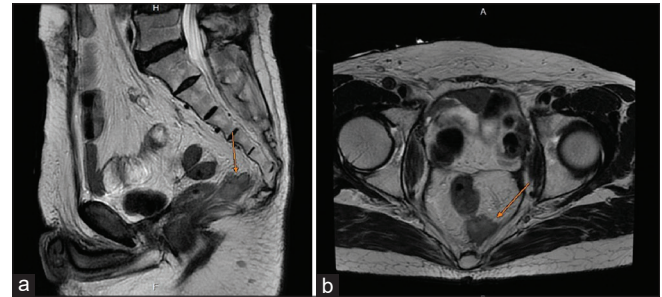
Abdominal magnetic resonance imaging (a: sagittal and b: axial view, T2) showing recurrent pelvic metastasis
